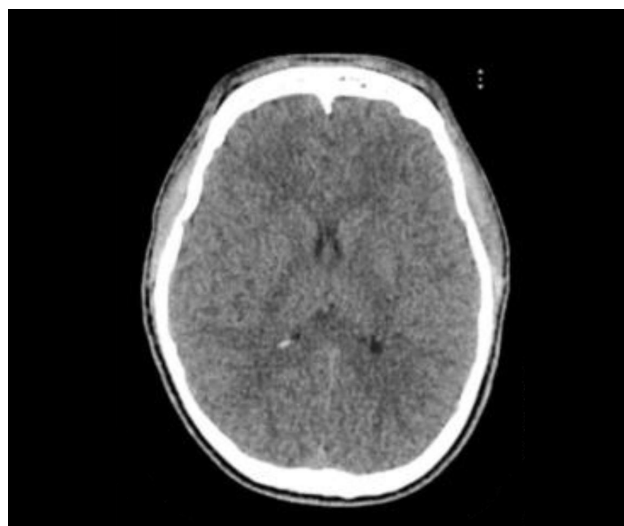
Computed tomography (CT) scan showed cerebral edema without hemorrhagic lesion.
